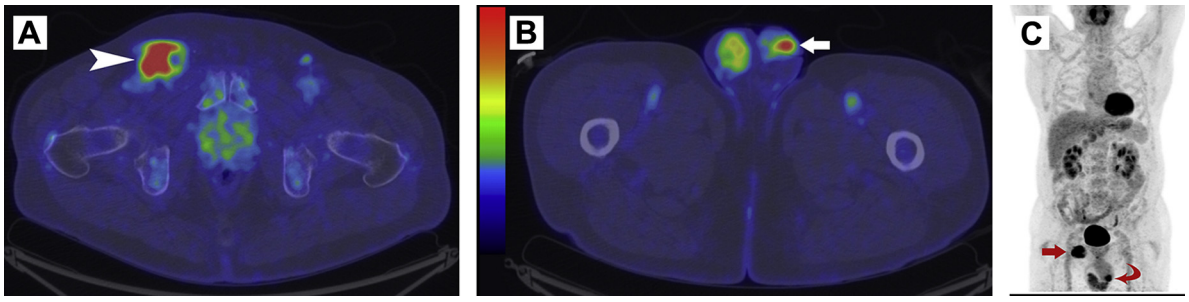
(A) Axial Fused Fluorine-18 Fluorodeoxyglucose (FDG) Positron Emission Tomography/Computed Tomography (PET/CT) Image Demonstrating a Markedly FDG-avid Right Inguinal Nodal Mass (White Arrowhead). (B) Axial Fused FDG-PET/CT Image Identifying a Focus of FDG Avidity at the Penile Tip (White Arrow). (C) Coronal PET Maximum Intensity Projection Image Demonstrating FDG-avid Right Inguinal Lymphadenopathy (Red Arrow) and FDG-avid Focus at the Penile Tip (Primary Cancer; Red Arrowhead)
